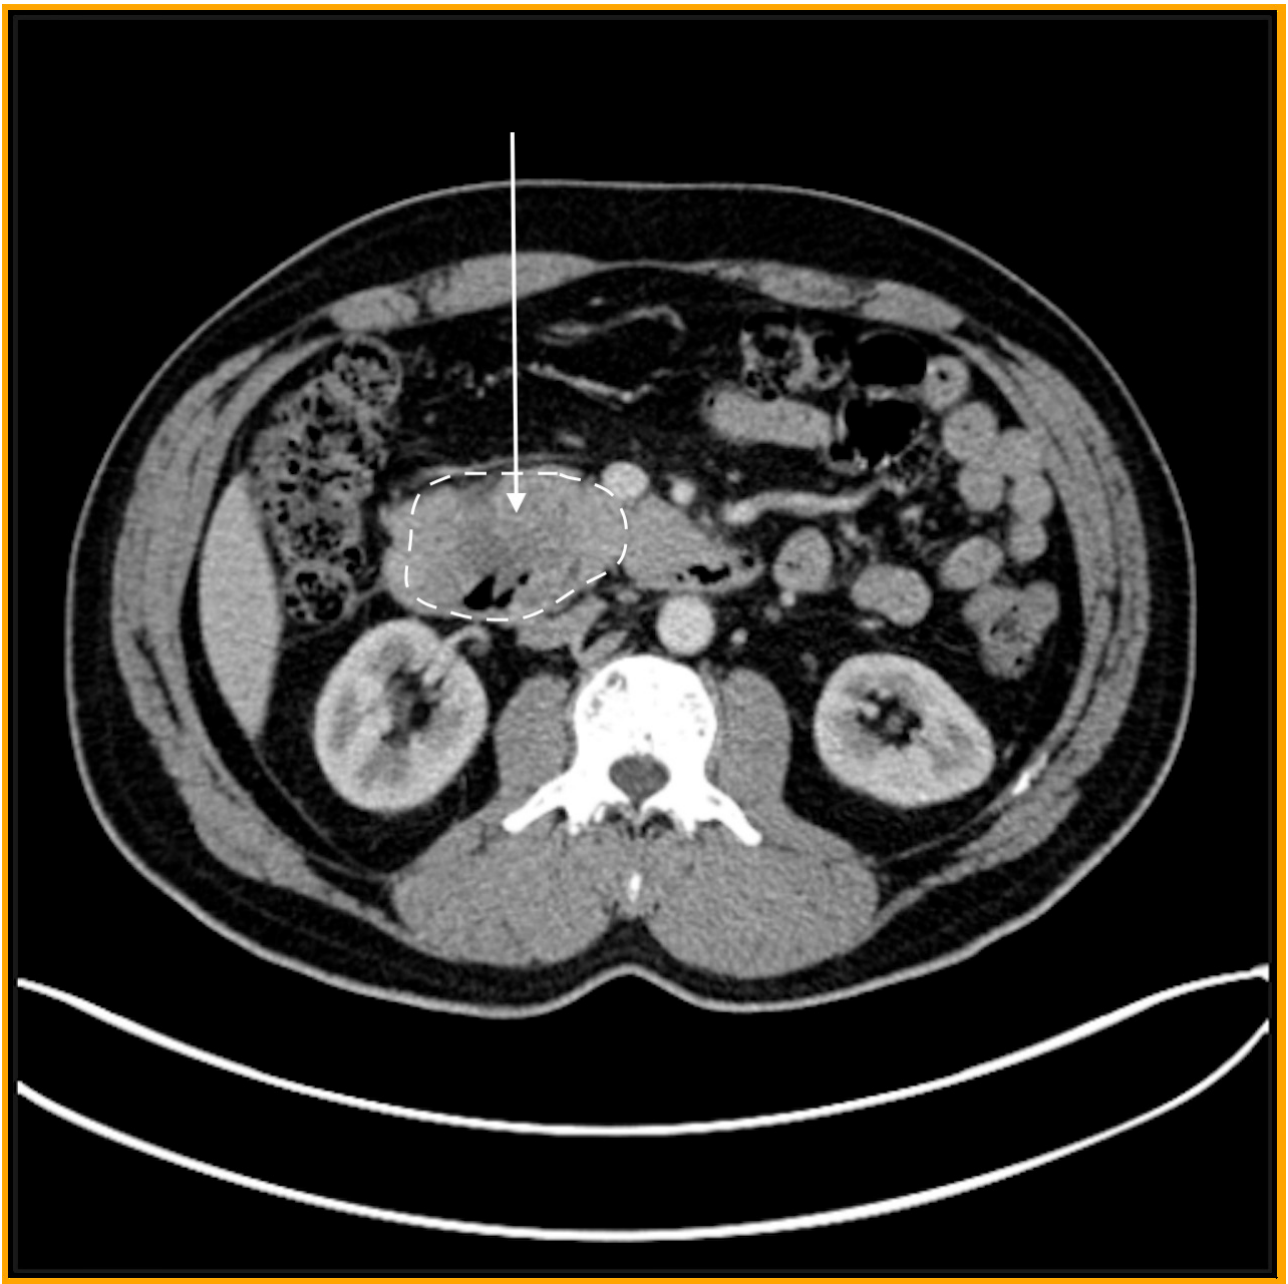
CT scan. Dotted lining showing the margins of the tumour.
